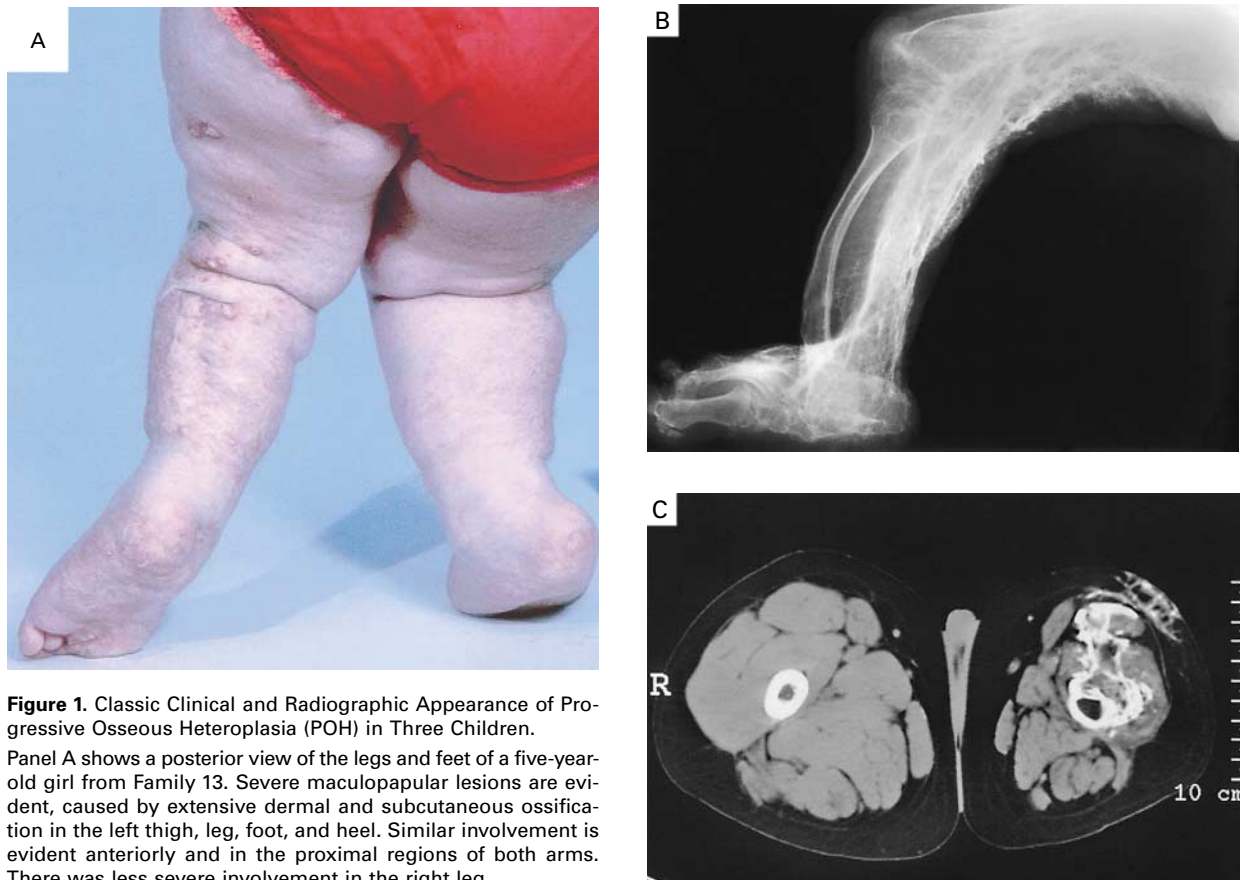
Classic Clinical and Radiographic Appearance of Progressive Osseous Heteroplasia (POH) in Three Children.
